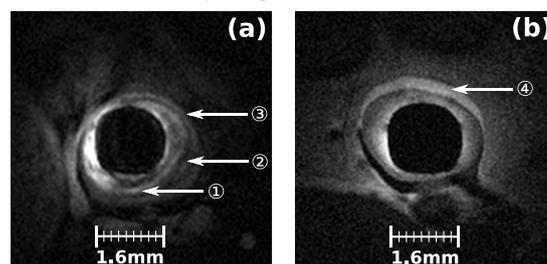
High resolution MR images obtain with the EC.
